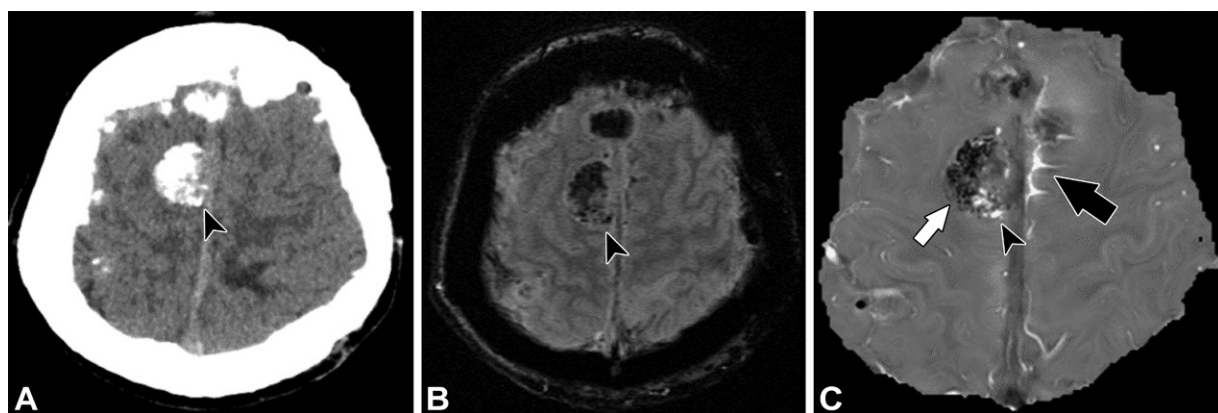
Meningioma of neurofibromatosis type 2 in a 34-year-old woman. (A) Axial CT image shows a high-attenuation nodule close to the falx (arrowhead). (B) Axial T2*-weighted MR image shows an area of signal hypointensity (arrowhead), which is suggestive of calcification or hemorrhage. (C) Axial QSM image demonstrates mixed signal intensity with areas of low and high contrast, indicating the coexistence of calcification (white arrow) and hemorrhage (arrowhead). Additionally, the QSM image shows hemosiderin deposition in the medial left frontal lobe (black arrow).
